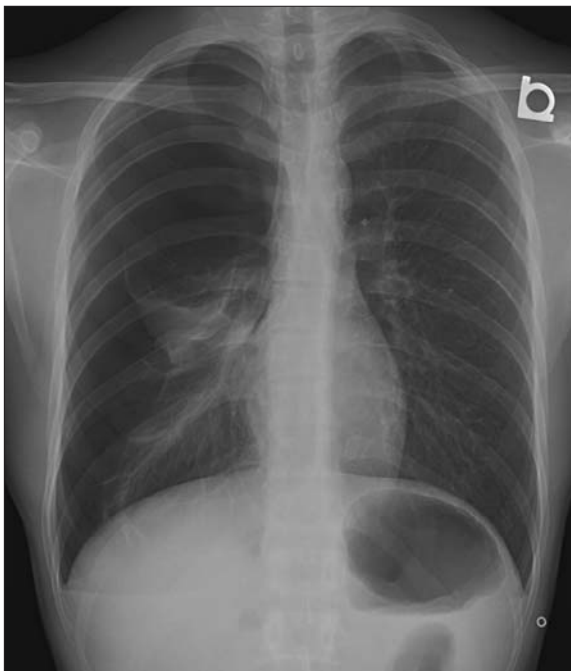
Initial x-ray, revealing a large pneumothorax.
